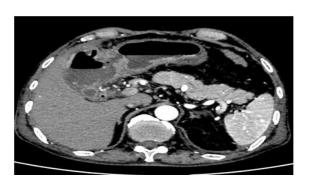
CT abdomen imaging showing fistulous communication with stomach and gall bladder following its perforation.
